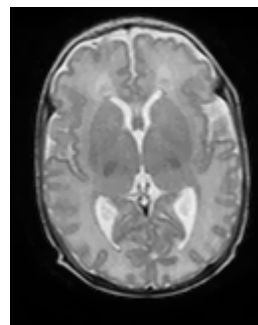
One axial slice of a T2 MRI volume of a premature newborn brain.
